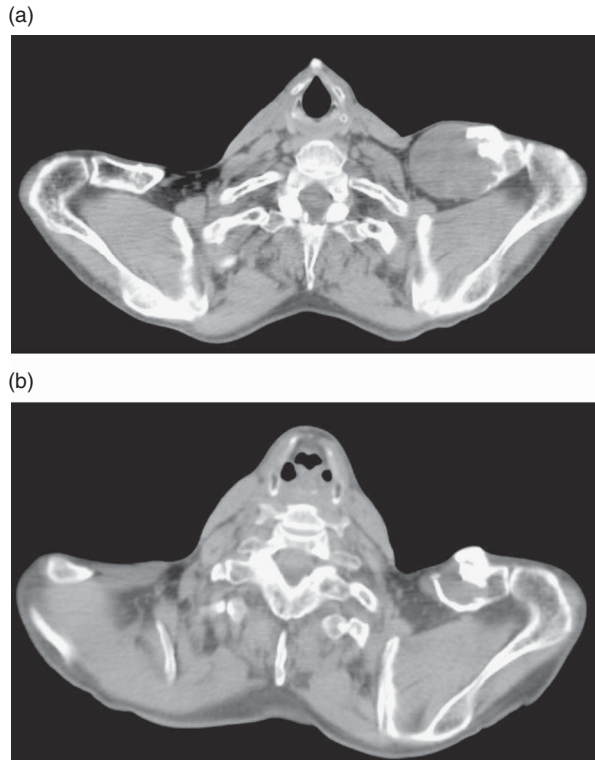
Computed tomography scan on 27 August 2012 shows large soft tissue mass arising in the left supraclavicular fossa with destruction of the left clavicle. The lesion was treated with 36 Gy in 9 fx's finishing on 17 September 2012. Follow-up imaging 7 months later on 11 April 2013 shows complete radiographic response to treatment.
